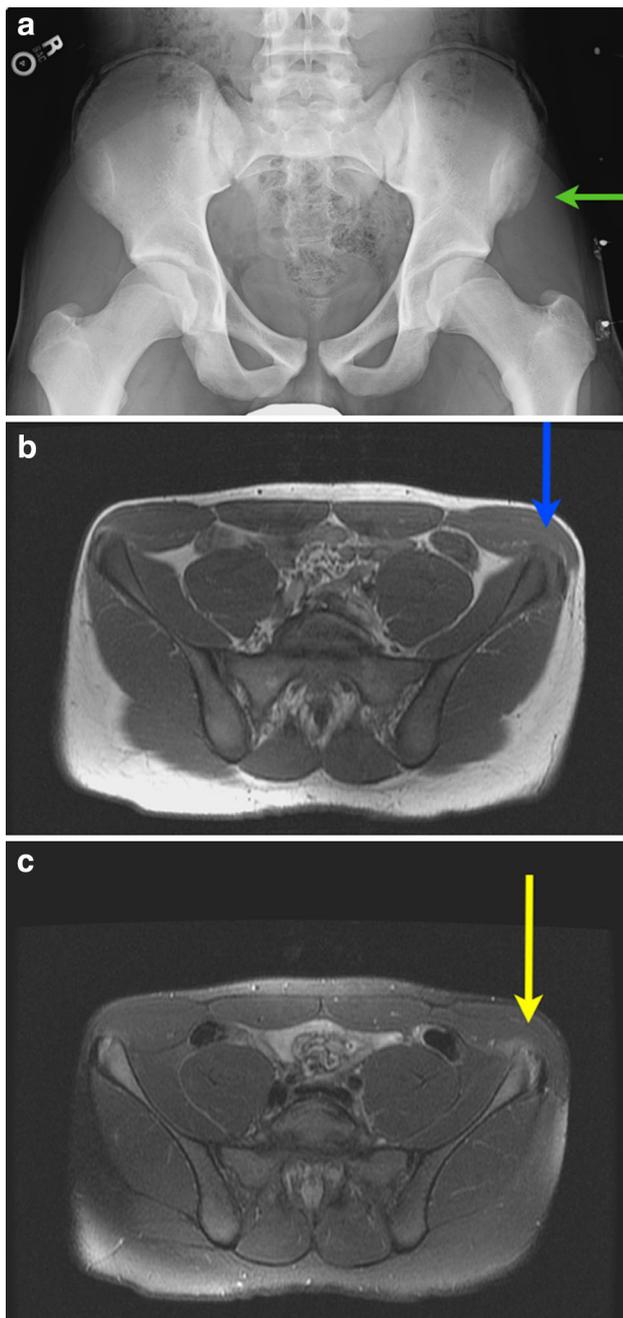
Diagnosis: apophysitis. A 15-year-old male with pain localized to the left anterior superior iliac spine, exacerbated by his participation in track. He was clinically diagnosed with apophysitis, which was confirmed by the pelvic radiograph and pelvic MRI. a An AP view of the pelvis demonstrates osseous irregularity and sclerosis at the left anterior superior iliac spine (*green arrow*), consistent with apophysitis. b An axial T1-weighted sequence shows osseous irregularity and physeal widening at the left anterior superior iliac spine (*blue arrow*). c An axial T2 fat-saturation sequence demonstrates mild marrow and soft tissue edema at the left anterior superior iliac spine with physeal widening (*yellow arrow*), confirming apophysitis (Color figure online)
